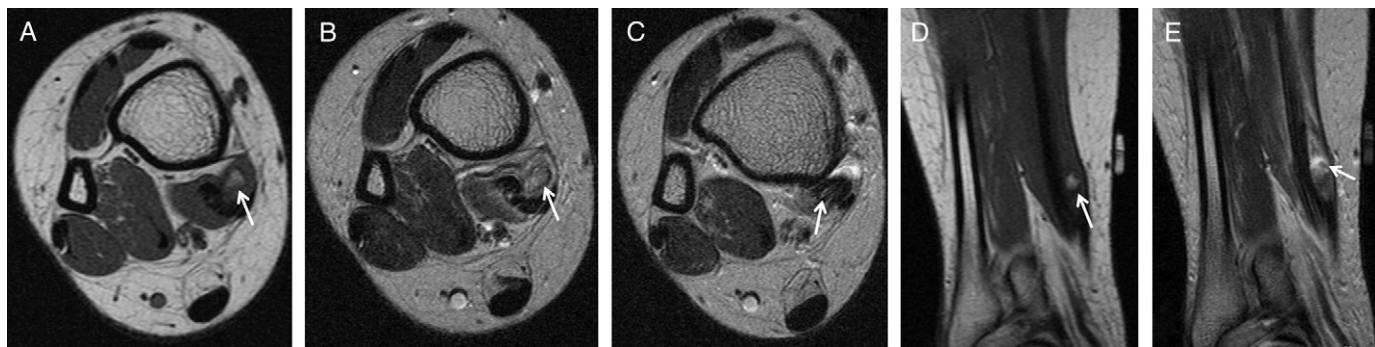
(A) T₁-weighted axial magnetic resonance imaging (MRI) scan showing bony mass (arrow) displacing the tibialis posterior (TP) tendon. (B) T₂-weighted axial MRI scan at the same level showing the bony mass (arrow) and TP tendon. (C) T₂-weighted axial MRI scan at the level of the distal conjoint TP tendon showing the osteochondroma and TP tendon (arrow), in which signal changes are noted, suggesting the tendon tear. (D) T₁-weighted coronal MRI scan showing tip of bony mass (arrow) protruding within the TP tendon and muscle. (E) T₂-weighted coronal MRI scan clearly showing osteochondroma (arrow) with overlying cartilage cap abutting the TP tendon.
